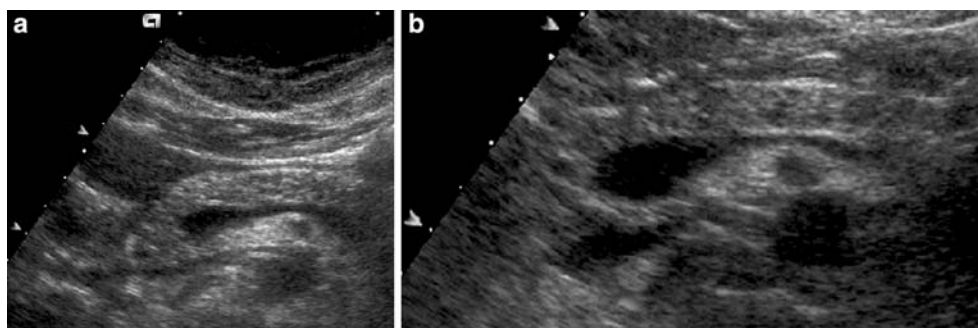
Chronic pancreatitis. Ultrasonographic examination (A) shows an inhomogeneous and coarse echotexture of the pancreatic gland due to the coexistence of hyperechoic and hypoechoic foci in the parenchyma, better visible in the detailed image (B).
